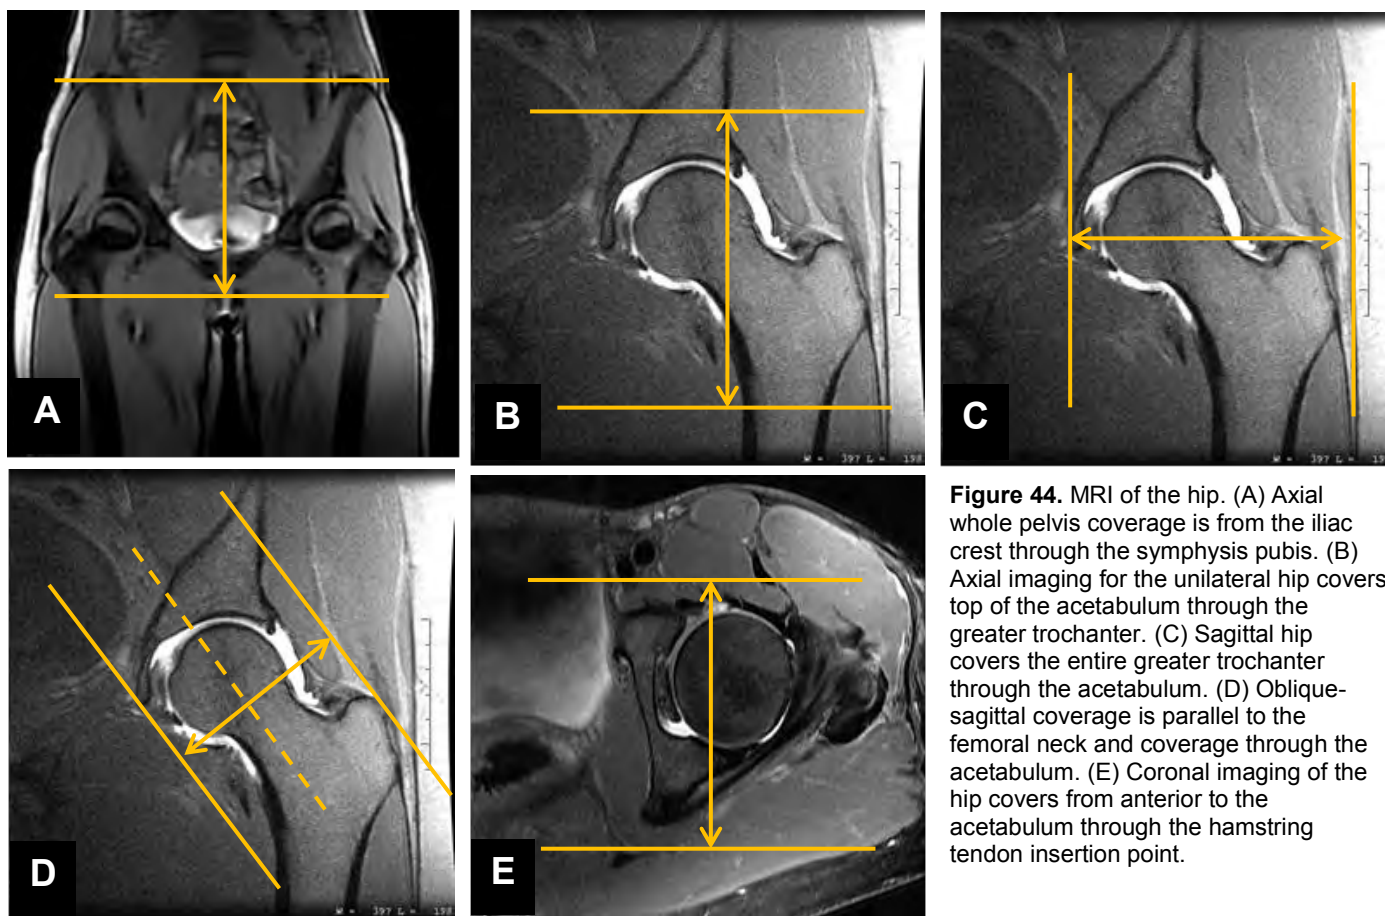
MRI of the hip. (A) Axial whole pelvis coverage is from the iliac crest through the symphysis pubis. (B) Axial imaging for the unilateral hip covers top of the acetabulum through the greater trochanter. (C) Sagittal hip covers the entire greater trochanter through the acetabulum. (D) Oblique-sagittal coverage is parallel to the femoral neck and coverage through the acetabulum. (E) Coronal imaging of the hip covers from anterior to the acetabulum through the hamstring tendon insertion point.
